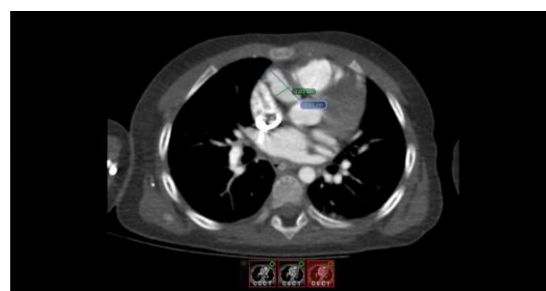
Cardiac CT showing a right coronary artery aneurysm.
